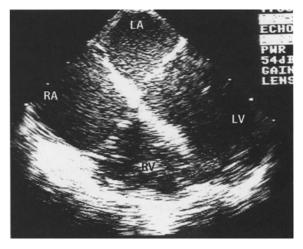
Cor triatriatum dexter (= divided right atrium): echocardiography. Postoperative echocardiography of the same patient as in Figs. 2.1.3 and 2.1.4 showing the complete resection of the Eustachian valve from the right atrium (LA left atrium LV left ventricle, RA right atrium, RV right ventricle) (reproduced with permission from Corno AF, Bron C, von Segesser LK (1999) Divided right atrium. Diagnosis by echocardiography, and considerations on the functional role of the Eustachian valve. Cardiol Young 9:427–429)
